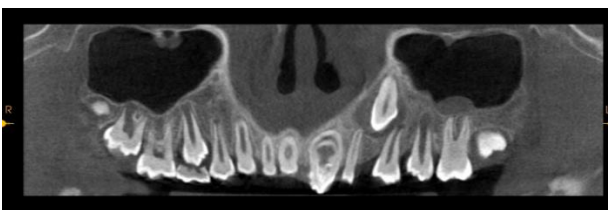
Preoperative coronally sectioned image of CBCT.
